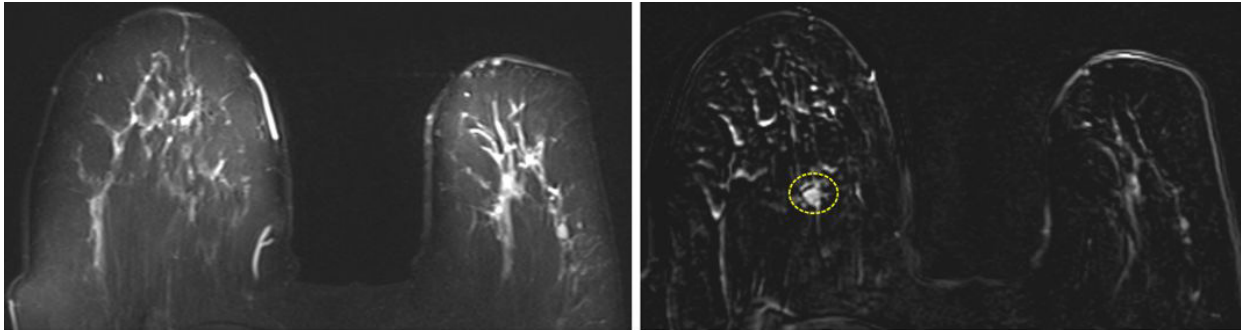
A 69-year-old female. No high signal was observed in the T2-weighted (T2W) image (right side). A heterogeneously enhanced 8-mm diameter mass was visible on the T1-weighted post-contrast subtraction magnetic resonance image (left side). It was categorized as a BI-RADS 3 lesion, and the patient was recommended for a follow-up magnetic resonance imaging after six months.
